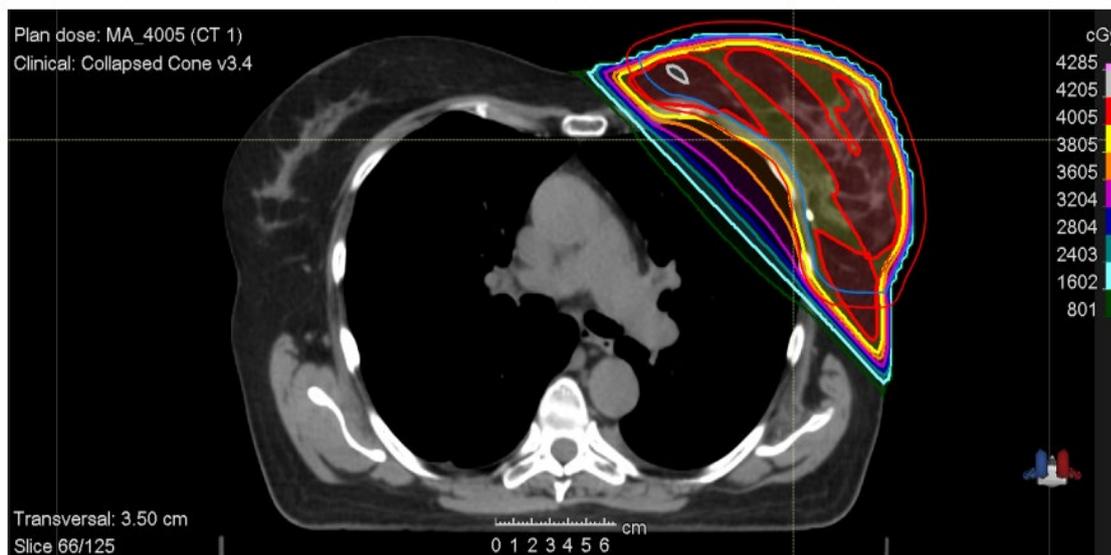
An axial CT slice through the middle of the breast
